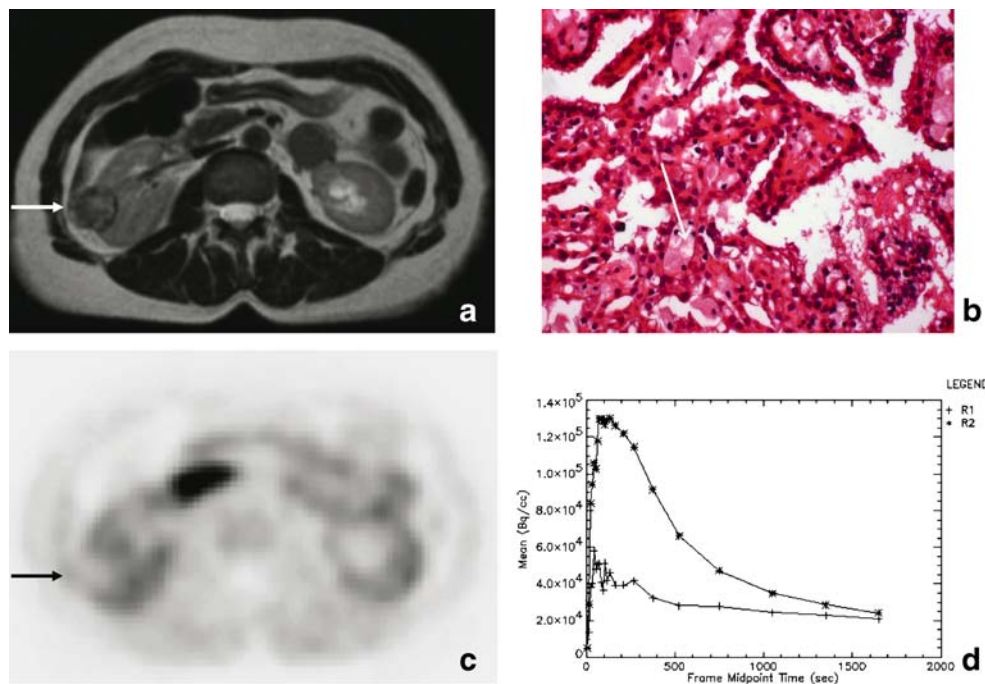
PET in a 54-year-old female (Table 1, patient no. 13) revealed a lesion of 30 mm in diameter in the right kidney (*white and black arrows*) without AC uptake (score=0). Time-activity curve of the lesion (*R1*) demonstrated no specific uptake of the lesion and washout kinetics comparable to normal kidney parenchyma (*R2*). T2-weighted MRI (turbo spin echo sequence) using a breath-hold technique visualised a slightly hypointense lesion as compared with the normal
